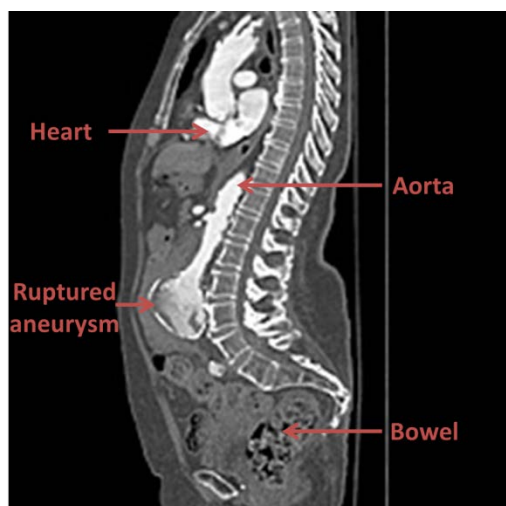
CT study timed at the arterial phase of the contrast bolus (CT angiography) demonstrates a ruptured abdominal aortic aneurysm (AAA). Static sagittal reformatted contrast enhanced CT. University of Massachusetts Medical School, Department of Radiology.
